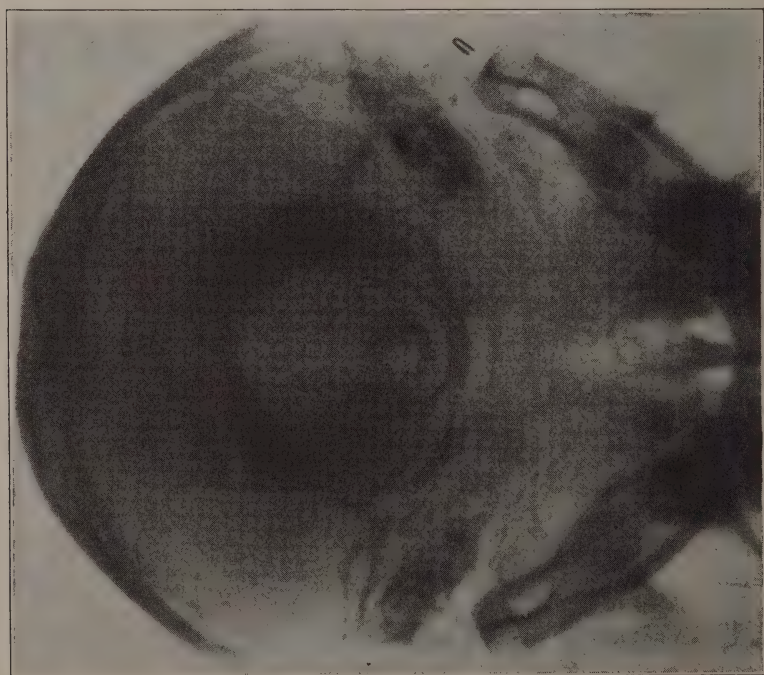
(*Case 8*). Roentgenogram taken with the patient in the Taylor position, ten days after operation. Note the complete loss of definition of the area of the apex tip.
